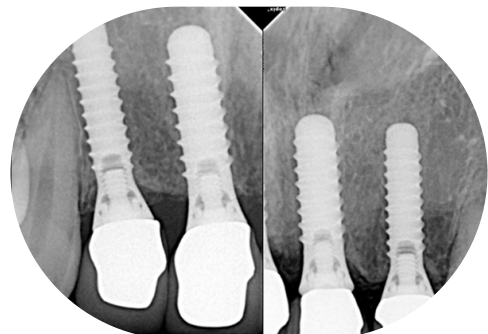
Intraoral radiographs of dental implants 10 years after treatment, the latest follow-up on Jan 17th, 2019.
